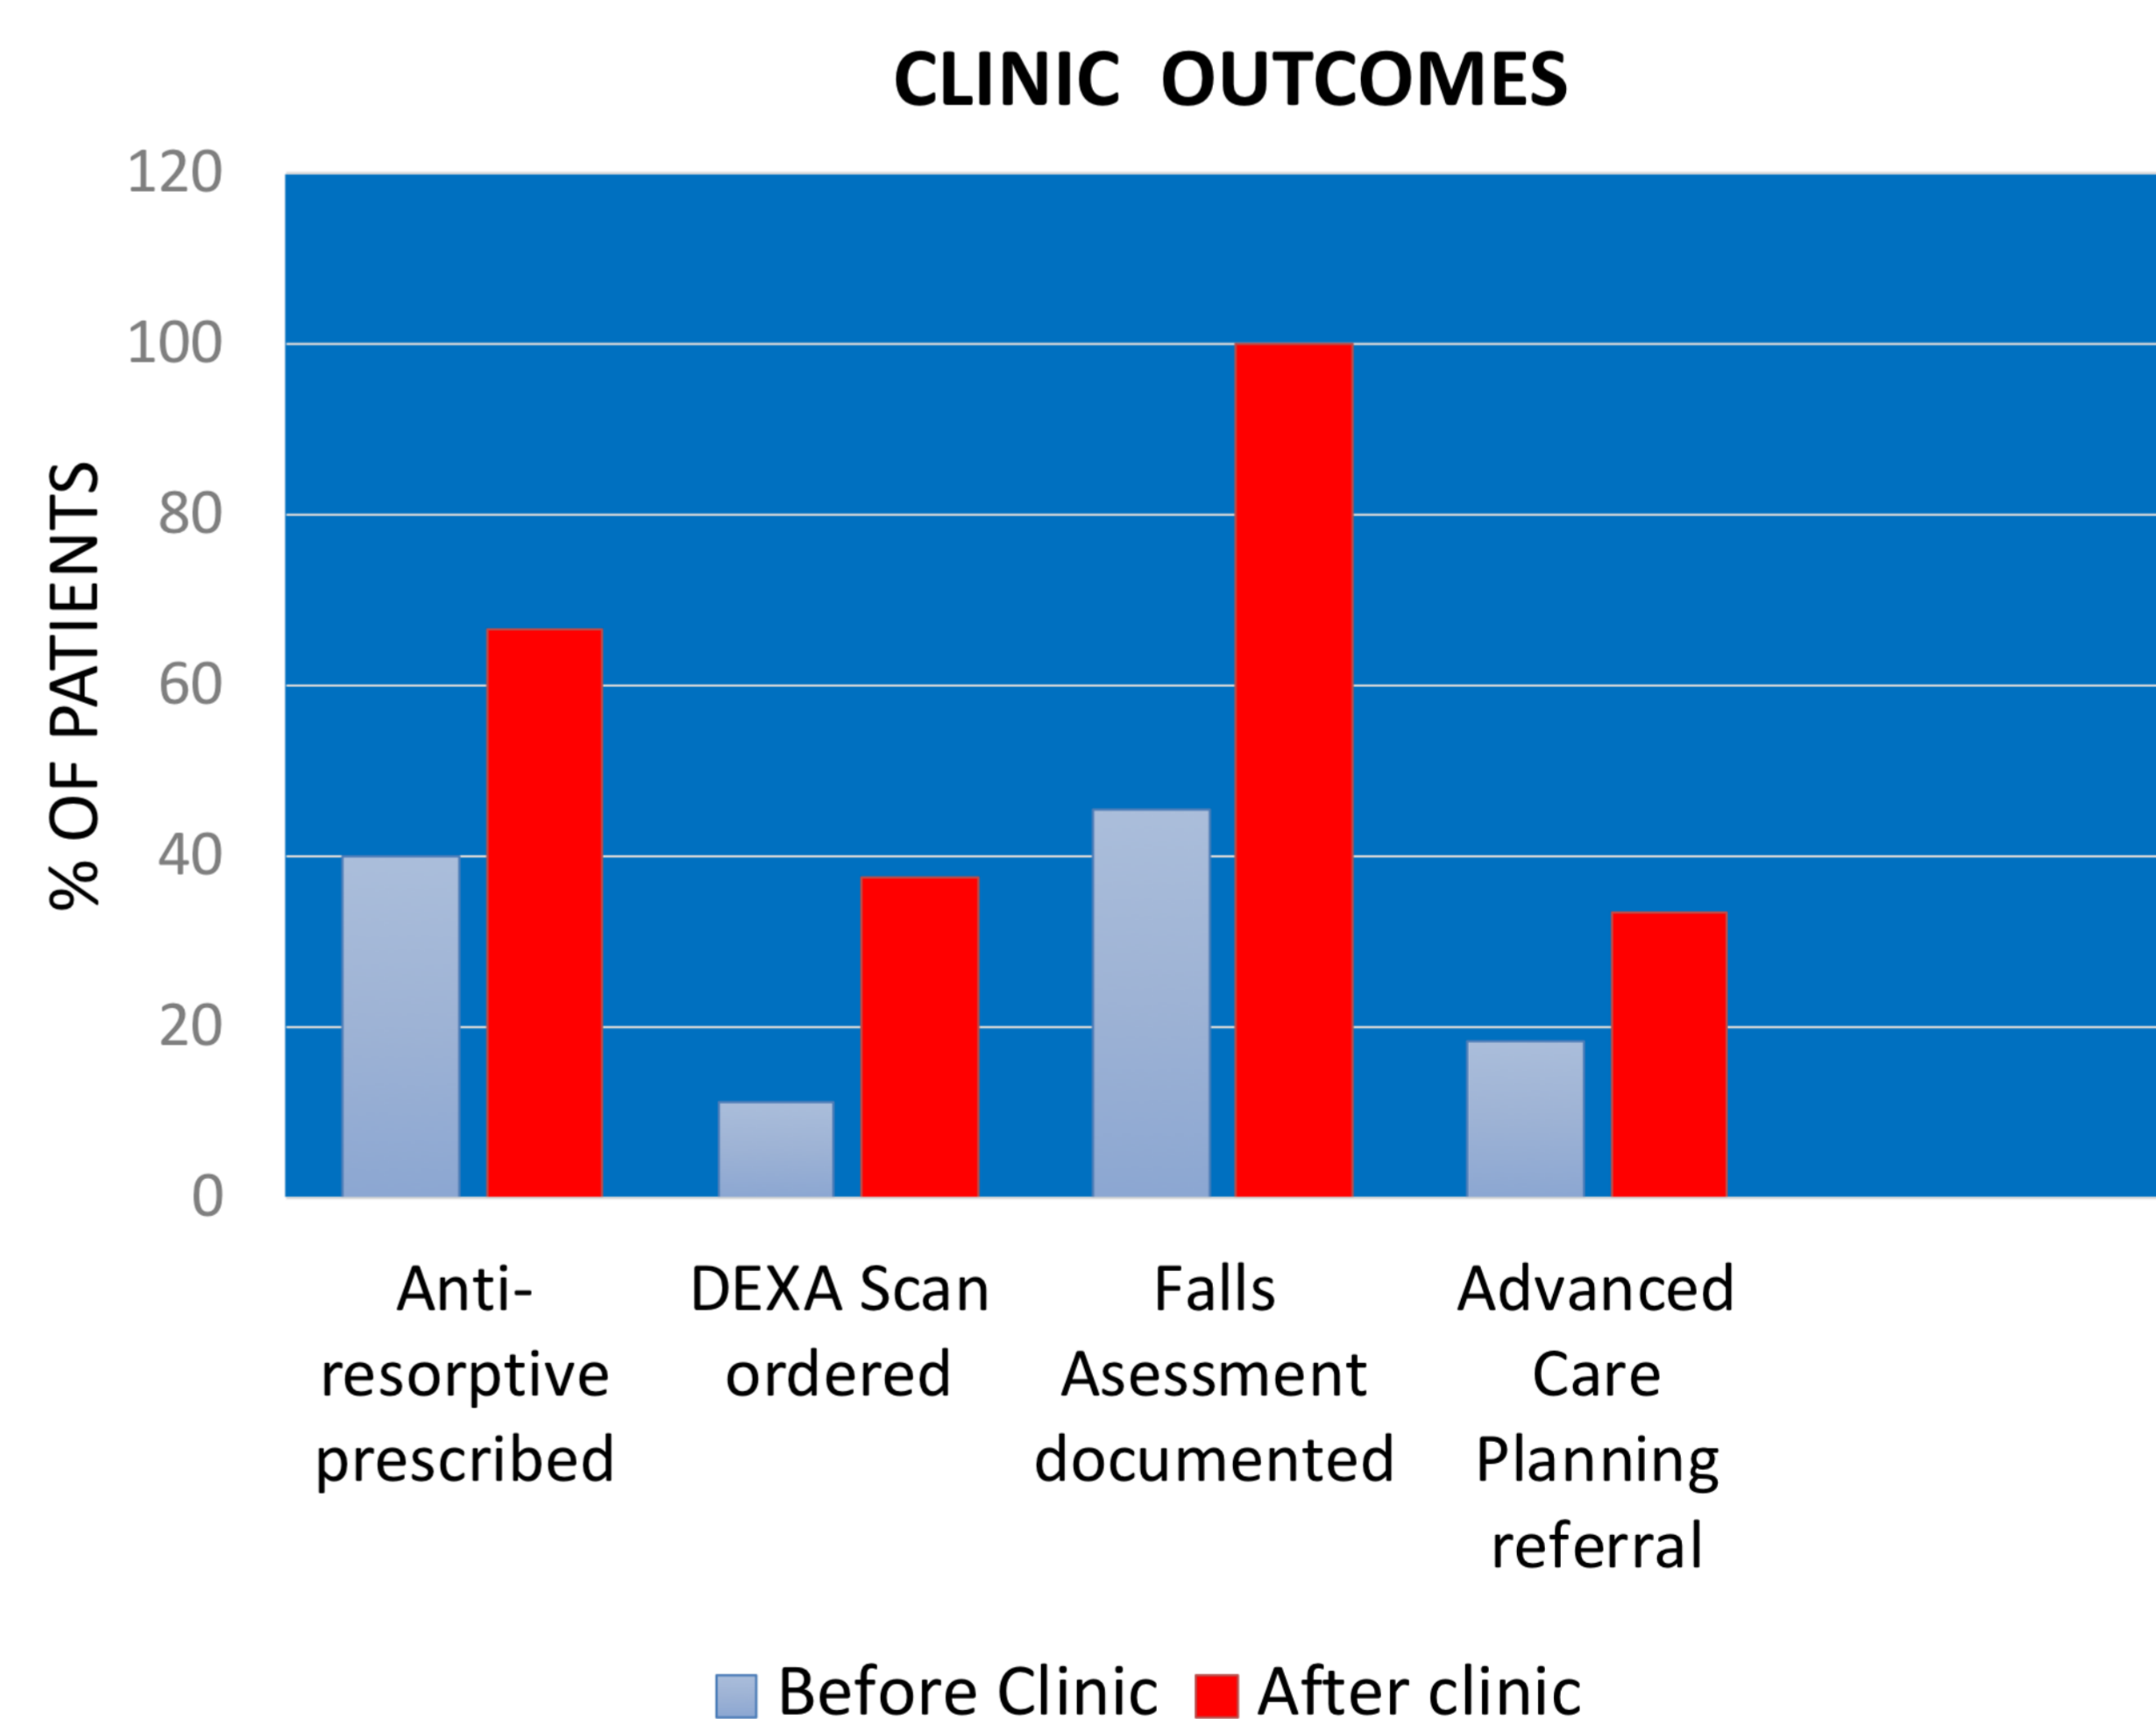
Clinic outcomes in anti-resorptive prescription, Dual energy x-ray absorptiometry (DEXA) Scan ordering, falls assessment documentation and advanced care planning referrals.
